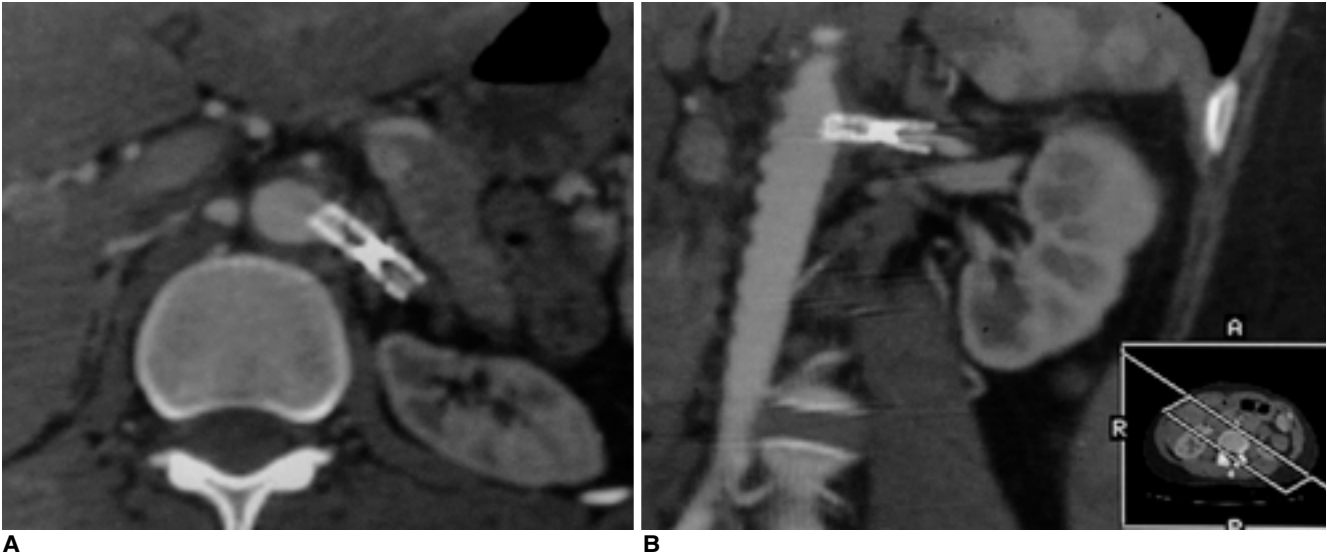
Multislice CT angiography was performed to evaluate the patency of a renal artery stent in a 21-year-old female. Reformatted images along the long axis of the Palmaz stent (A, oblique axial; B, coronal views) shows stenosis in the mid portion of the stent due to insufficient expansion.
